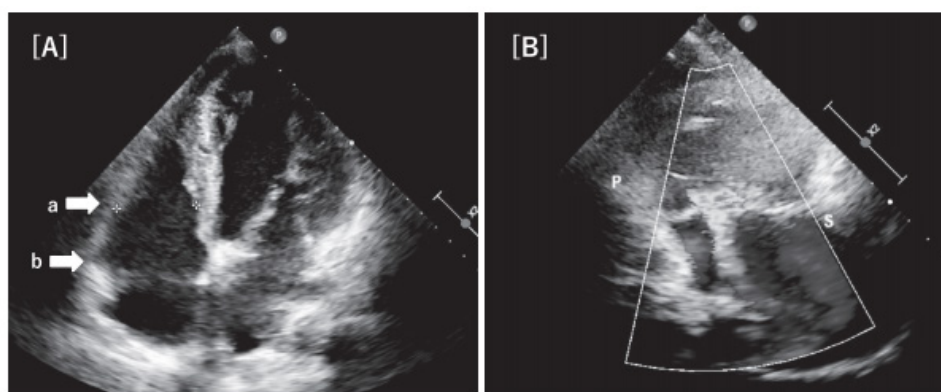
Preoperative transthoracic echocardiography. (A) In the four-chamber view, arrow a points to the functional tricuspid annulus, and arrow b points to the anatomical tricuspid annulus. Celermajor index = 0.28. (B) In the apical 2-chamber view, S is the septal leaflet, and P is the posterior leaflet. TR moderate.
